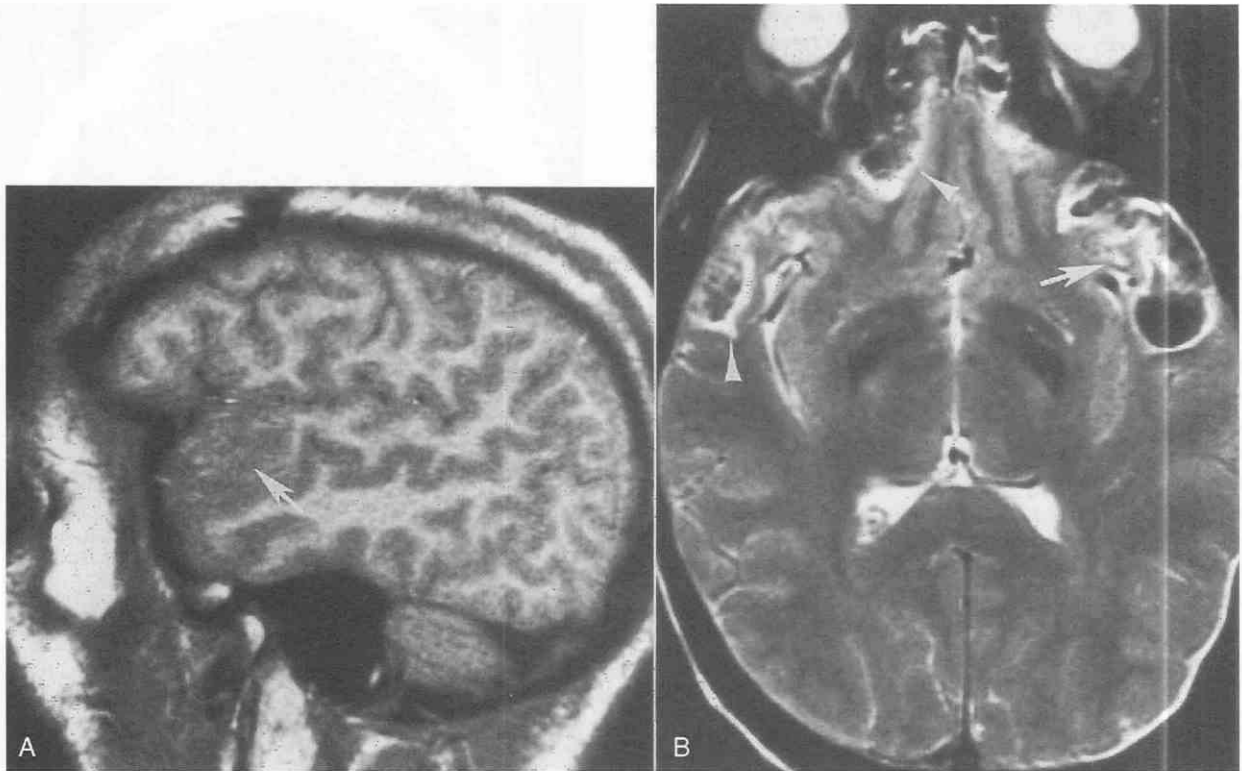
A, Acute left temporal lobe hemorrhagic contusion is isointense with gray matter on sagittal T1-weighted (500/15) MR image (arrow). B, Hemorrhagic contusion is hypointense on axial T2-weighted (2500/80) image (arrow). Note additional hemorrhagic contusions in the right frontal and temporal lobes (arrowheads).
